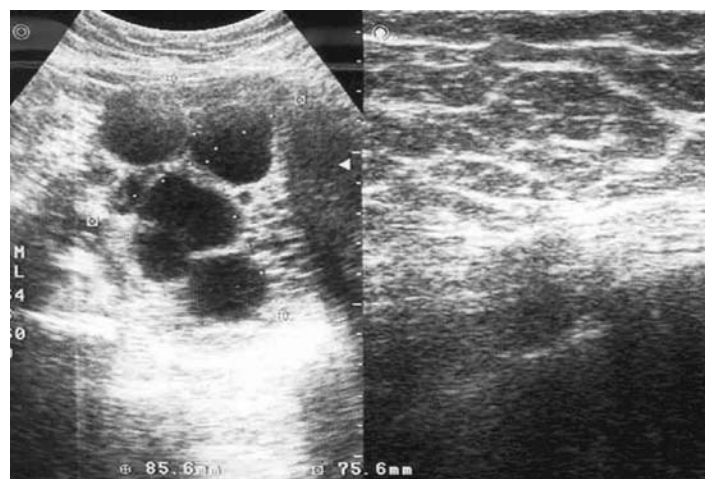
Sonographic appearance of the oviduct hydatid cyst showing.
